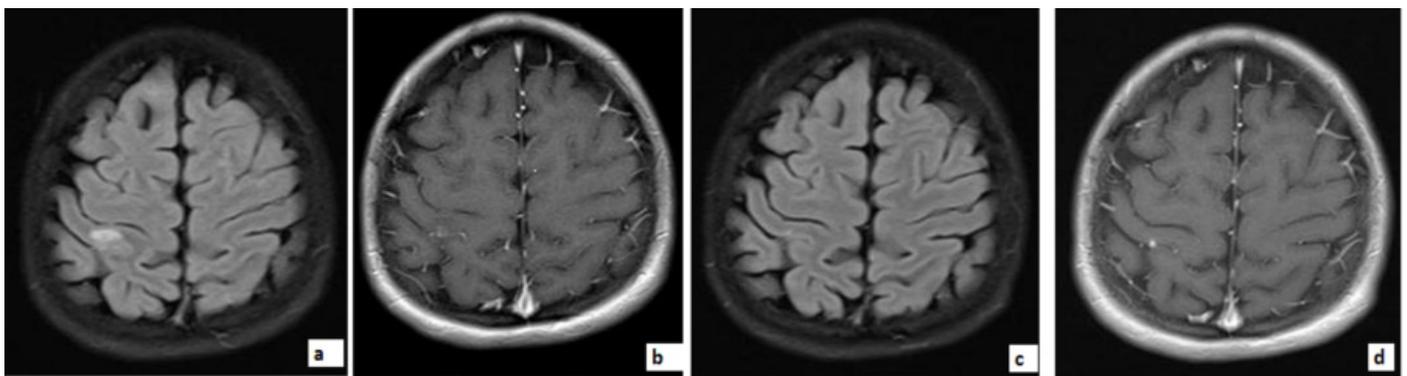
Area of hyperintense edema (Figure 4a) on the axial FLAIR image and contrast enhancement on the post-contrast T1-weighted axial image (Figure 4b) in post-transplant brain MRI, were found compatible with focal cerebritis in the 21-year-old female patient who underwent liver transplantation due to hypercholesterolemia. In the control brain MRI of the patient after the treatment findings were improved (Figure 4c, 4d).
